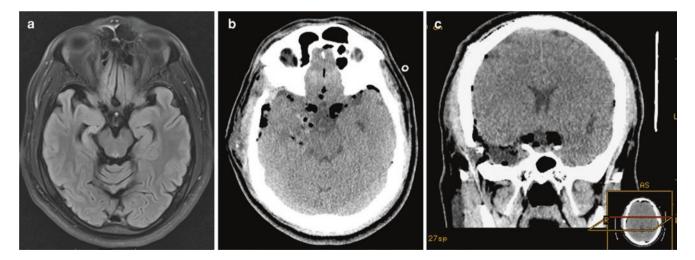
In a 36-year-old man with a long history of epilepsy, preoperative magnetic resonance imaging showed atrophy of the right hippocampus, suggestive of mesial temporal sclerosis (a). Anterior temporal lobectomy with amygdalohippocampectomy was done, but, in the immediate postoperative period, the patient experienced seizures with a
